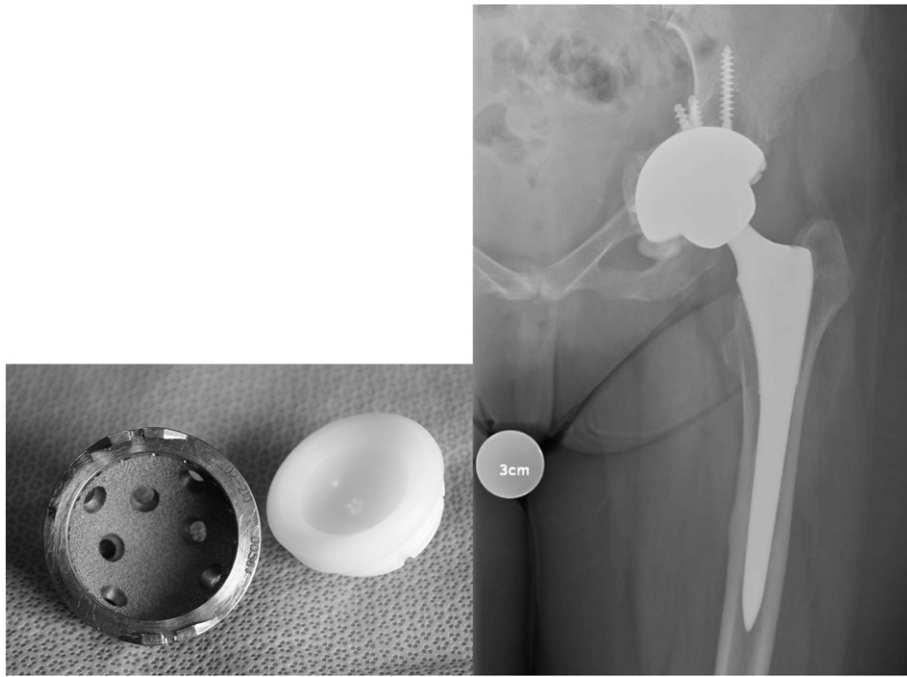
Photographic and radiographic image of a TM Revision Shell (Zimmer, Inc).
